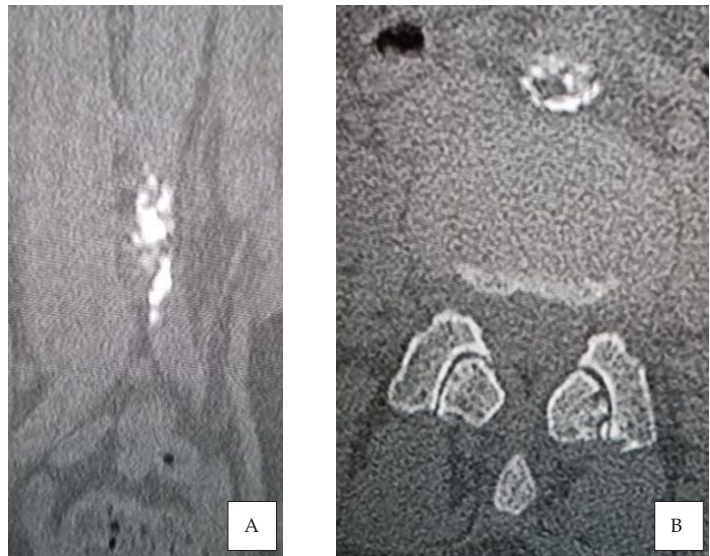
CT scan of fibrocalcified atheromatous plaque at aortic bifurcation level with a 60-65% stenosis: A) coronal view, B) axial view.
